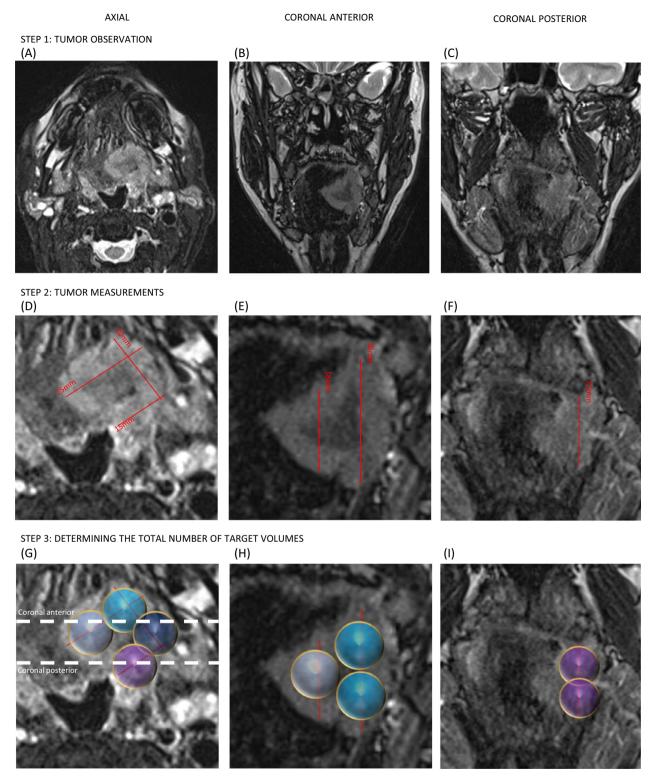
Example of IT planning using pre-injection MRI. (A, D, G) Axial; (B, E, H) coronal anterior; (C, F, I) coronal posterior. Dashed lines in (G) show the correspondence between axial and coronal images. (A-C) Step 1, tumor observation. (D-F) Step 2, tumor measurements. (G-I) Step 3, determining the total number of target volumes represented here by the spheres. Spheres of the same color represent similar location on the axial plan. Here, one light blue, two intermediate blue, two dark blue (not shown in coronal) and two purples volumes are planned, for a total of seven target volumes. [Color figure can be viewed at wileyonlinelibrary.com]
